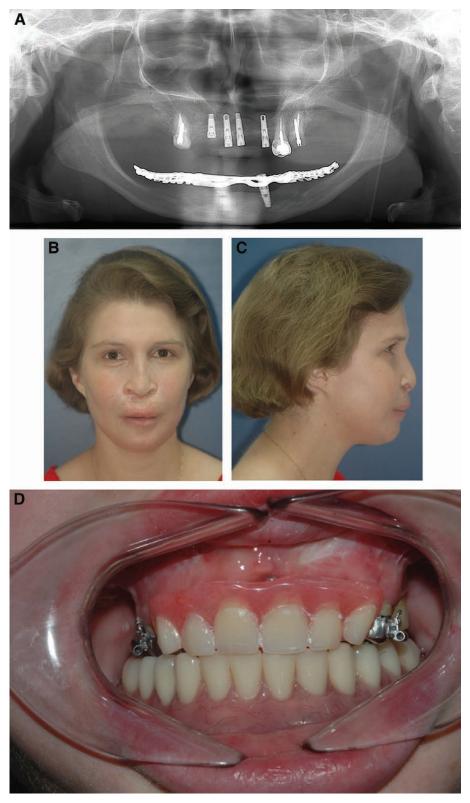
Following dental rehabilitation. A, Panoramic radiograph showing the placement of dental implants in the maxilla. B, C, One-year postdistraction clinical photographs demonstrating normognathic facial appearance, notice the convex profile and the paranasal bony support. D, Prosthetic rehabilitation supported by the dental implants.
